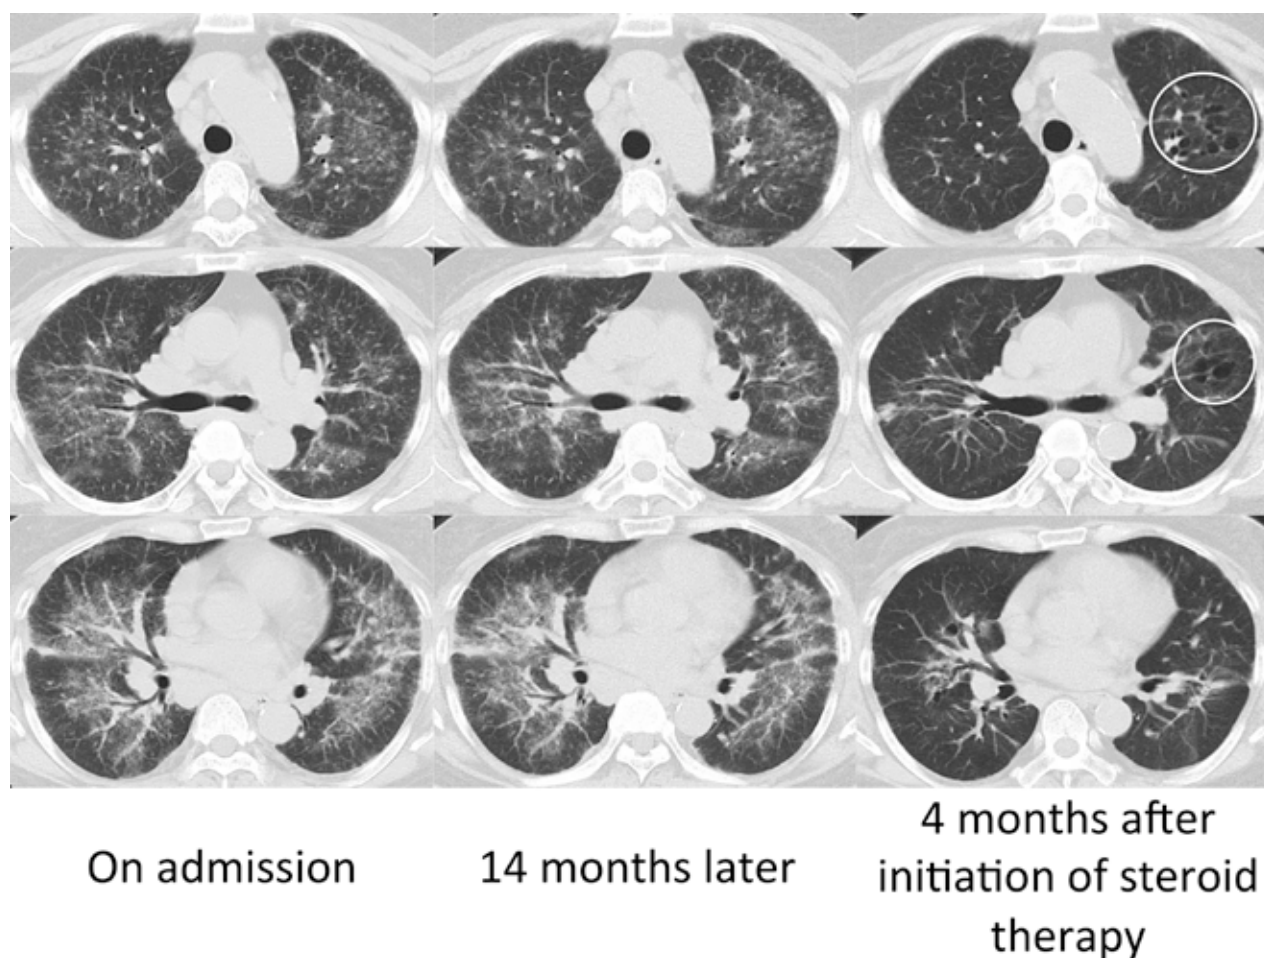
Clinical course of computed tomography (CT) findings. Compared with chest CT findings associated with sarcoidosis on admission, cystic lesions had appeared in the left upper lobe and multiple granular shadows in both lungs had increased 14 months later. Four months after the start of steroid therapy, the granular shadows had almost disappeared, but the left upper lobe cystic lesion (indicated by white circles) remained.
